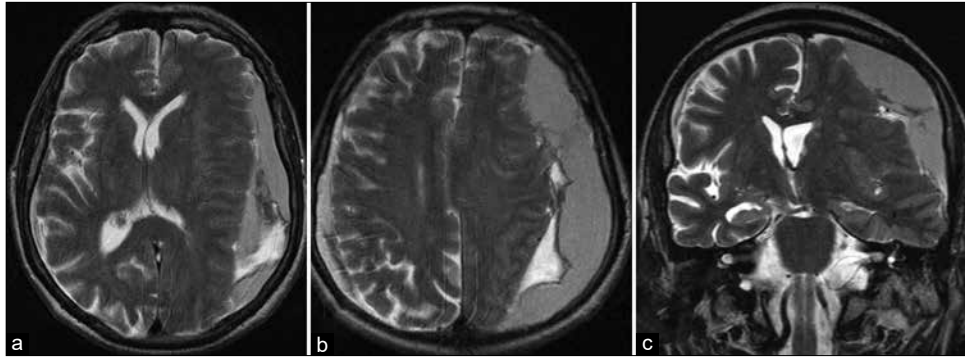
Initial MRI scans of patient 2. (a and b) T2 MRI, axial plane, (c) T2 MRI, coronal plane. Massive cSDH presented with slight compression on the left hemisphere.
